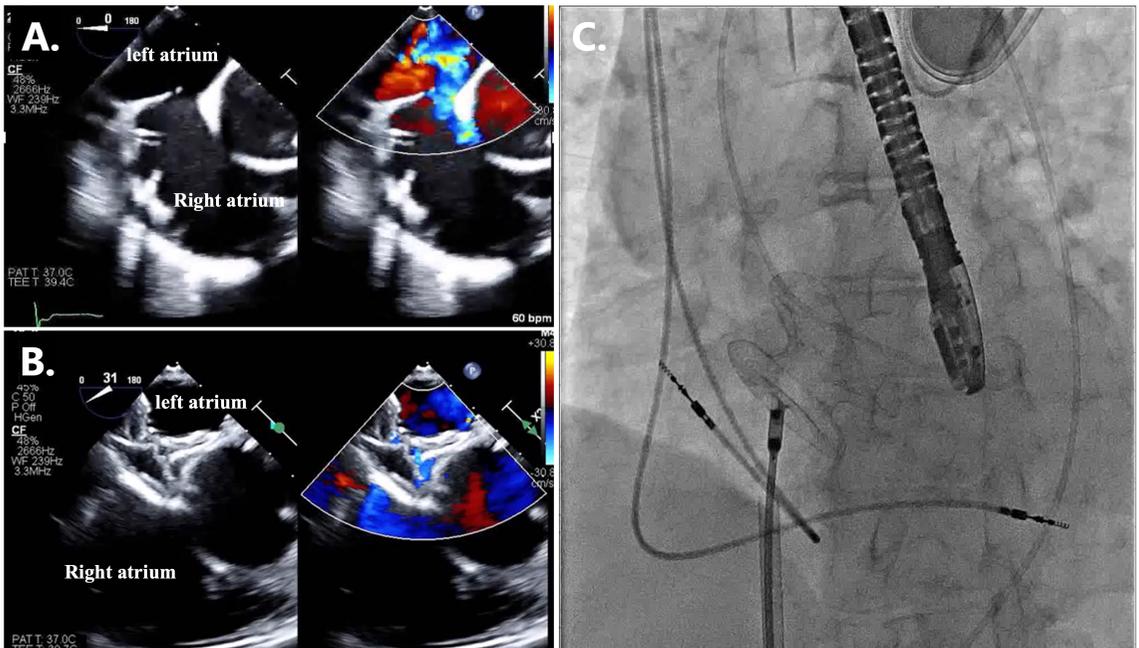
Transthoracic echocardiographic and fluoroscopic images during ASD closure
